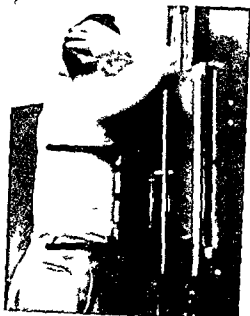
A lead scale suspended parallel to the cassette in the plane of the anterior axillary line is recorded on the roentgenogram Projection magnification is of the same order as the heart and reduction in miniature films is likewise identical The scale recorded in the roentgenogram serves as reference for cardiac measurement
